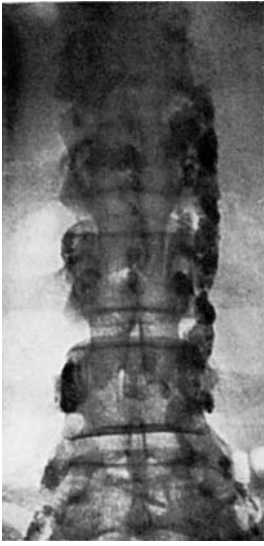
Control radiography of the field limits. Contrast-filled lymph nodes are visible in the field.
